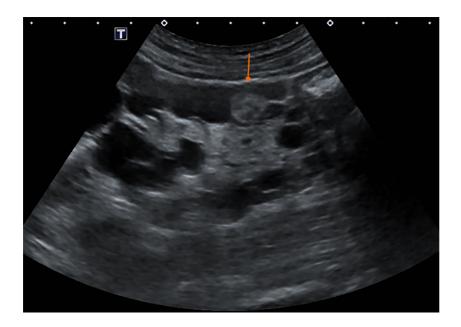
Ultrasonography revealing a 1.5-cm hyperechoic nodule in the left kidney.
